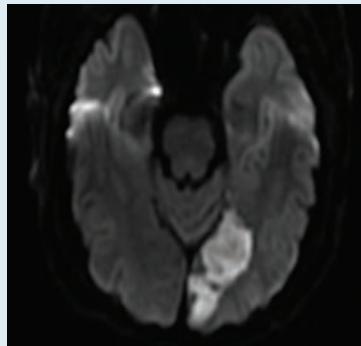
These axial T2/FLAIR, left, and DWI, below, MRI images show hyperintensity in the left occipital lobe extending to the left temporo-occipital region, consistent with the patient's left posterior cerebral artery territory acute/subacute infarct.
